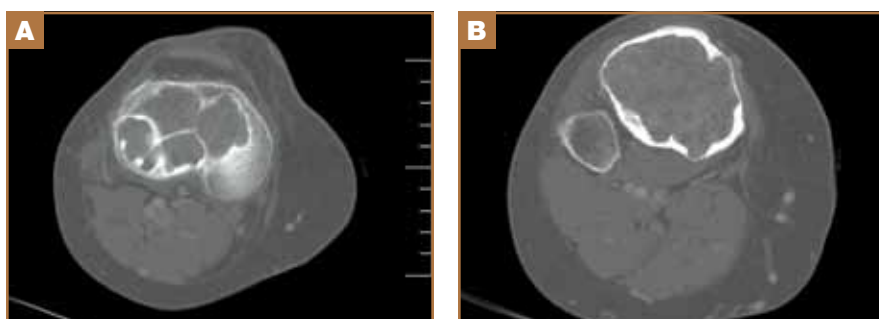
Axial computed tomography of the right knee (A and B, proximal and distal aspects of the lesion, respectively) shows an expansile lytic lesion of the proximal tibia with thin septations and areas of endosteal scalloping. The lesion is approximately 6x5 cm near the articular surface. There is no cortical destruction, soft-tissue extension, or periosteal reaction.
